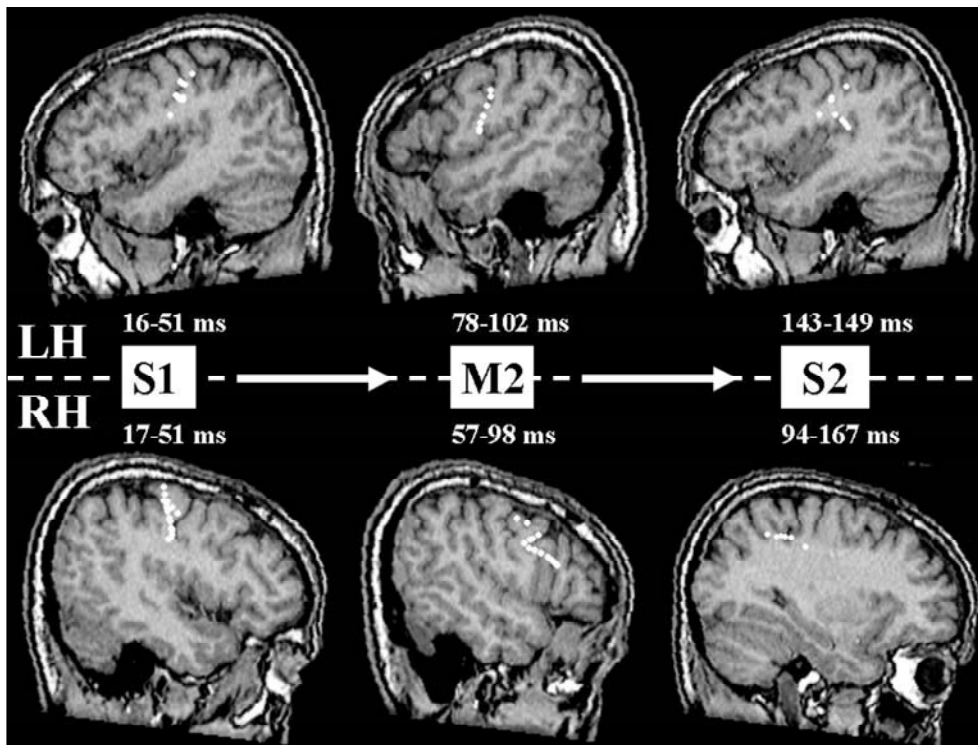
Dipole localization during the IM trial (white dots overlapped in a single MRI slice). Dipoles represent the temporal sequence of cortical activation during the first 200 ms after contralateral index finger stimulation.
